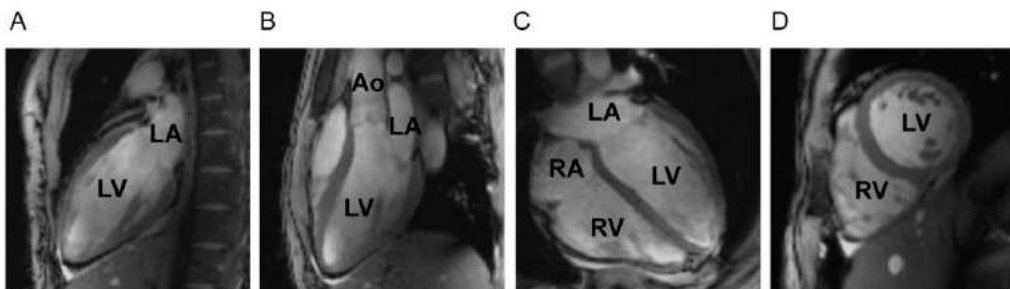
Typical cardiac views. (a) 2 chamber view (b) 3 chamber view (c) 4 chamber view (d) mid-ventricular short axis (SAX mid) view. Images acquired using an MRI 7.0 T scanner and a RF 16-channel array transceiver.
